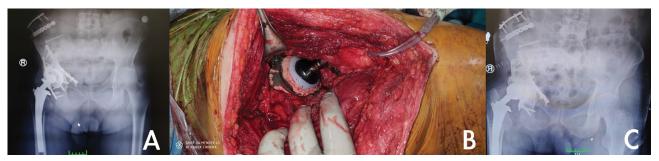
A. Pelvic ring failure and cup malposition 89 months after the revision operation; B. Revision intraoperative image with cage + nonconstrained cup; C. Post-operative radiograph.
